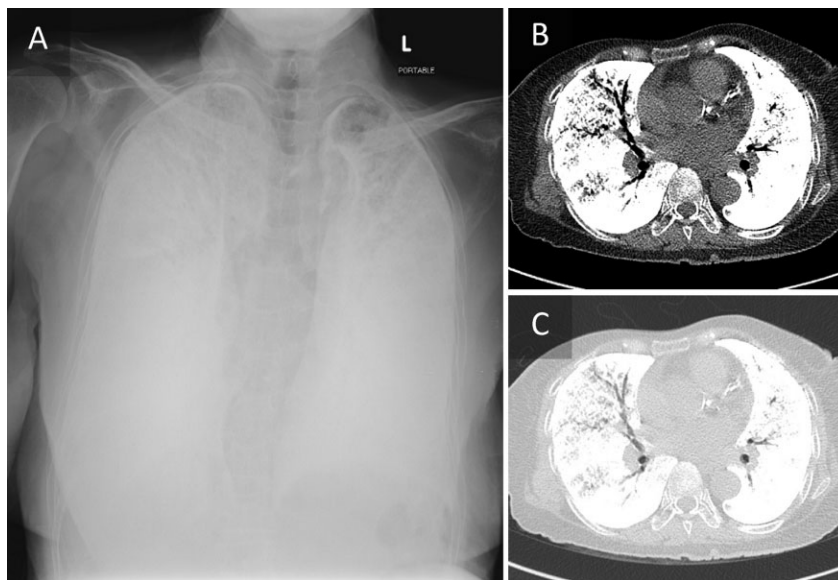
Chest radiograph (A) and high-resolution computed tomography of chest in mediastinal window (B) and lung window (C) demonstrated bilateral extensive calcification diffusely involving both lungs.
